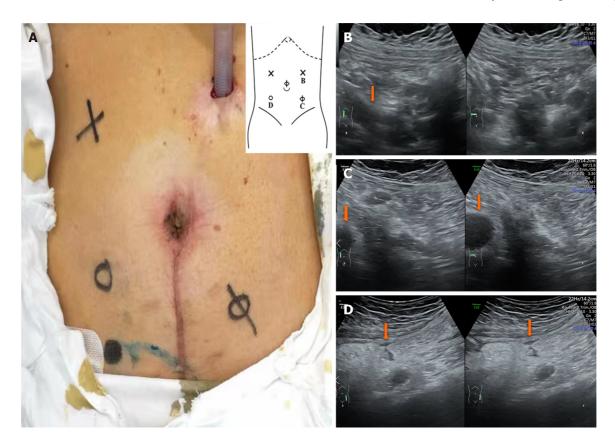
With the changes during respiration, B-ultrasonography was used to examine different areas to determine the activity between the abdominal wall and viscera. A: The degree of intraperitoneal adhesion is indicated by the annotations "x", "\P", and "loop". "x" means that the activity is mm, and moderate intraperitoneal activity and moderate adhesion are considered. "loop" means that the activity is less than 5 mm, and severe adhesion is considered; B: In (A), the area denoted "x" in the left upper abdomen is seen under ultrasound. The blood vessels disappear from the screen, as shown in the arrow. Considering that there is no adhesion, it is the first place to puncture; C: In (A), the area denoted " Φ " in the right lower abdomen is seen under ultrasound. The range of intraperitoneal vessels with respiration is shown by the arrow; D: In (A), the area denoted "loop" in the right lower abdomen is seen under ultrasound. The range of intraperitoneal vessels with respiration is shown by the arrow.
